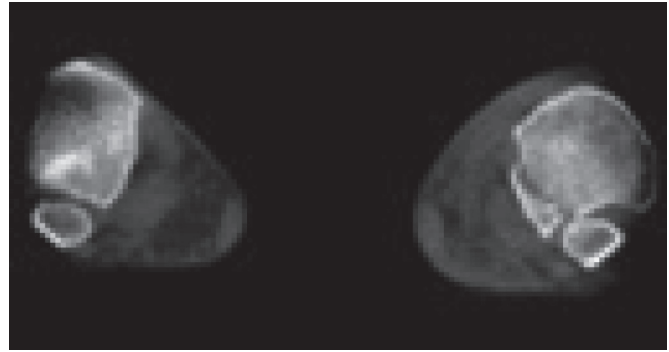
Sagittal translation of the fibula (on the right side) at gravity ER stress in intraoperative CT scan.
